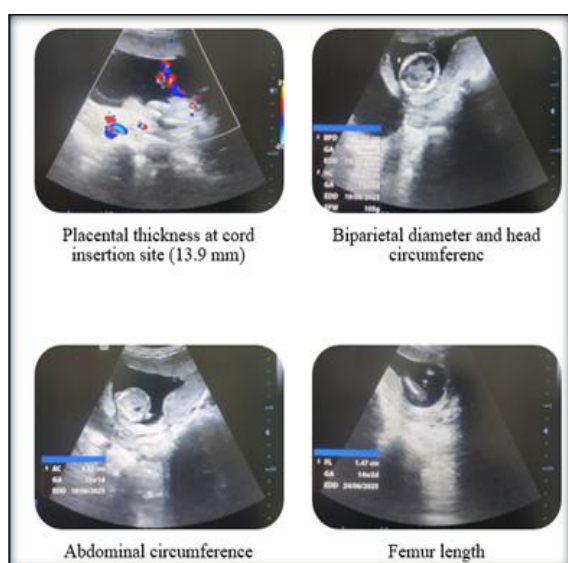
Case 3 showing Ultrasonographic Assessment of Placental Thickness and Fetal Biometry at 32 Weeks Gestation
